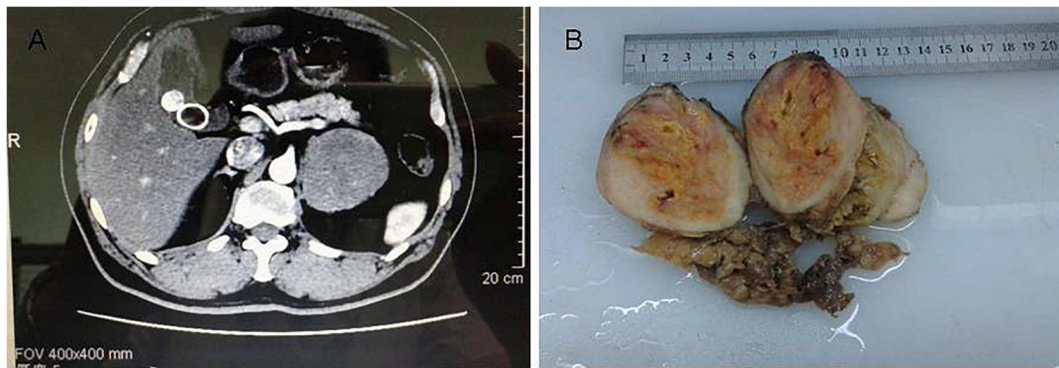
A: Computed tomography (CT) scan showed the left adrenal gland; B: the tumor presented a well-defined demarcation with 7 cm × 6 cm in maximum cross-section with a uniform density.
